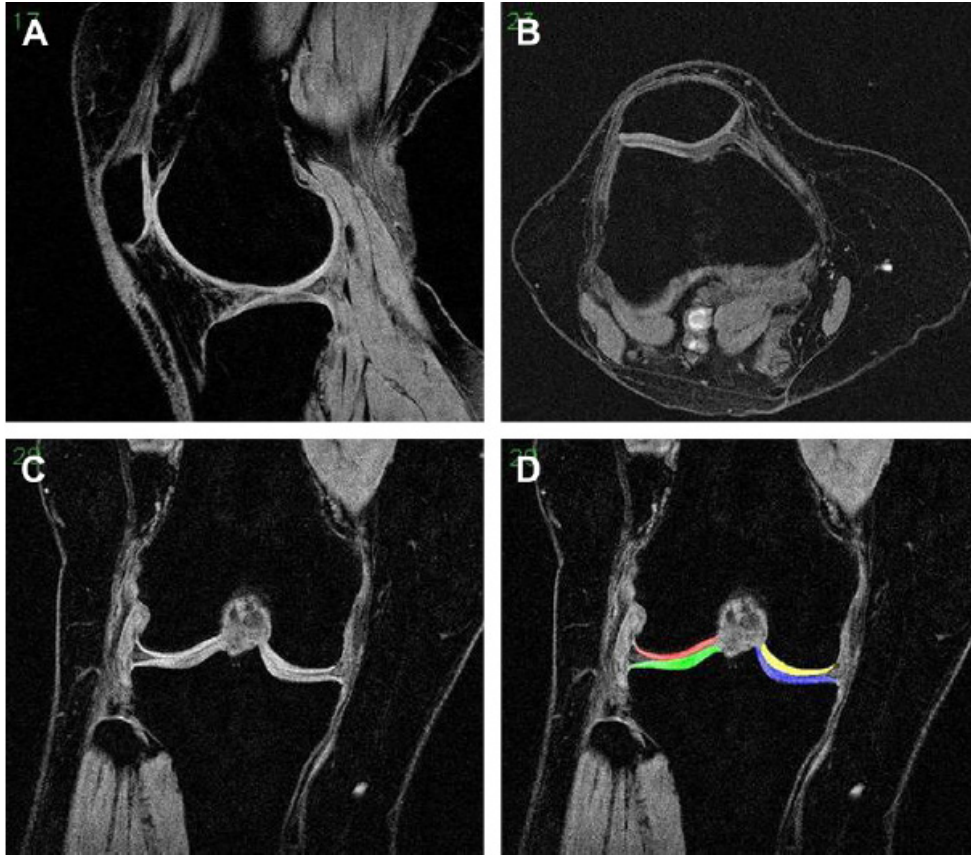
Knee MR image obtained with spoiled gradient-echo (SPGR) sequences with water excitation, in the same person: (A) sagittal image; (B) axial image; (C) coronal image; (D) same coronal image with the medial tibial cartilage marked (segmented) blue, medial femoral cartilage marked yellow, lateral tibial cartilage marked green, and lateral femoral cartilage marked red.
